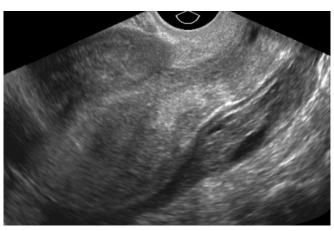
Transvaginal ultrasound of the uterus does not demonstrate an intrauterine gestational sac
